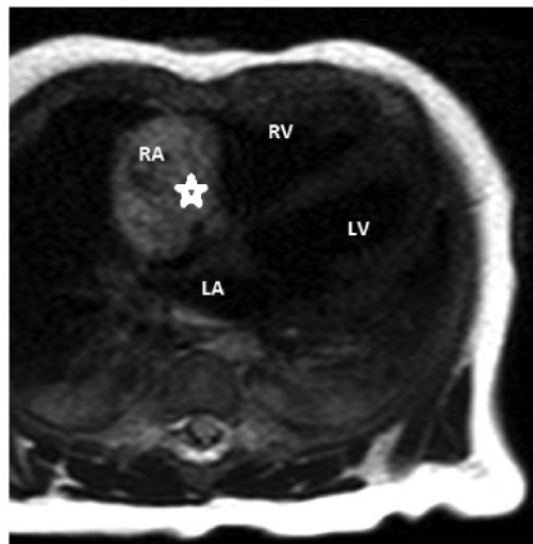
Case 2: cardiac magnetic resonance imaging at 2 months of age showing a mass measuring 28 mm in diameter isointense on T1 sequence. The star is marking the mass.
